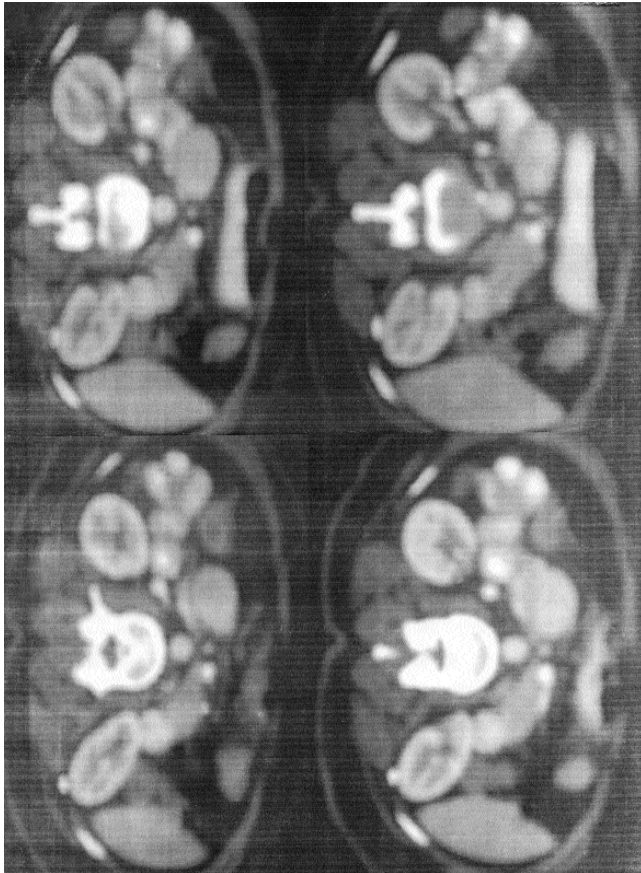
Oral and IV contrasted CT scan. A solid mass with homogeneous contrast enhancement at the duodenal wall.
